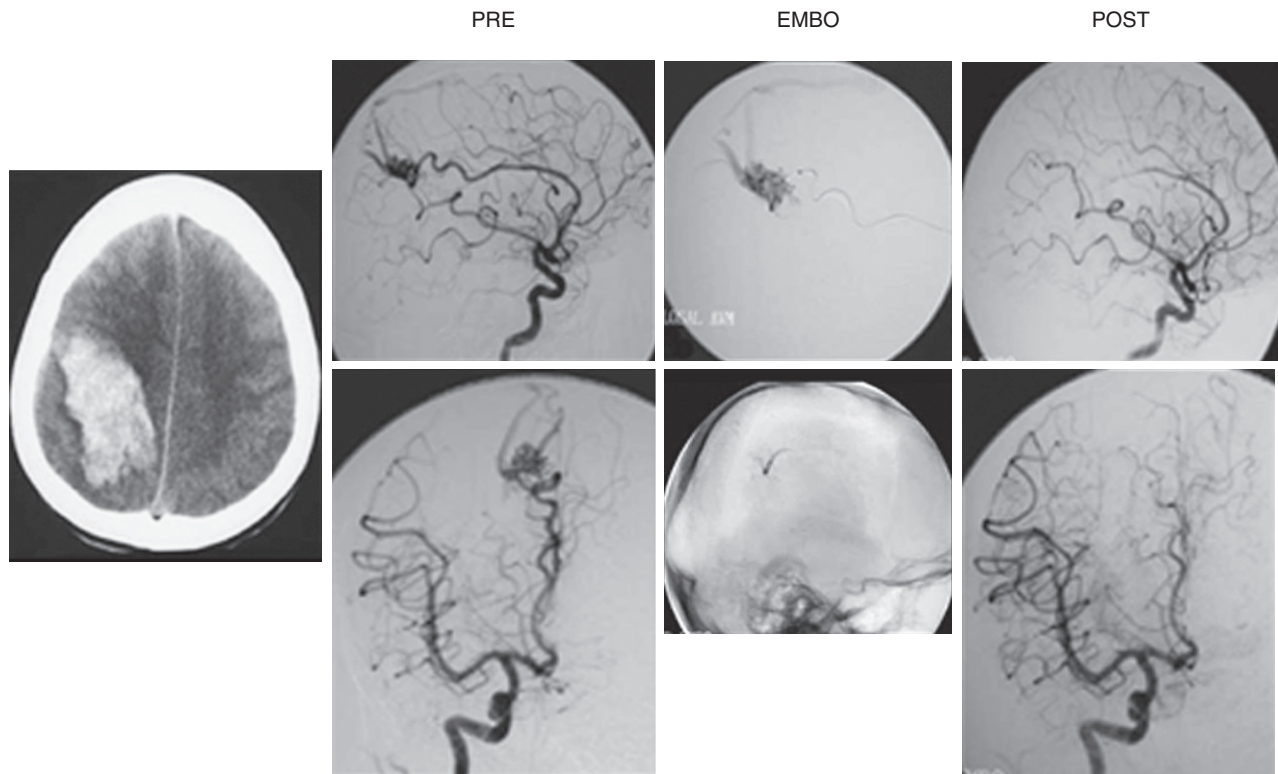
Endovascular treatment of a ruptured right parietal arteriovenous malformation (AVM). Left, CT scan shows acute parenchymal hemorrhage. Pre-embolization (PRE), mid-embolization (EMBO), and post-embolization (POST) angiographs show placement of a flow-directed microcatheter into the feeding artery and embolization using cyanoacrylate glue, with complete eradication of the AVM. Pre and post-embolization images are lateral (top) and anteroposterior (bottom) projections. Middle views show the microcatheter in the AVM during progressive occlusion; both are lateral projections.
